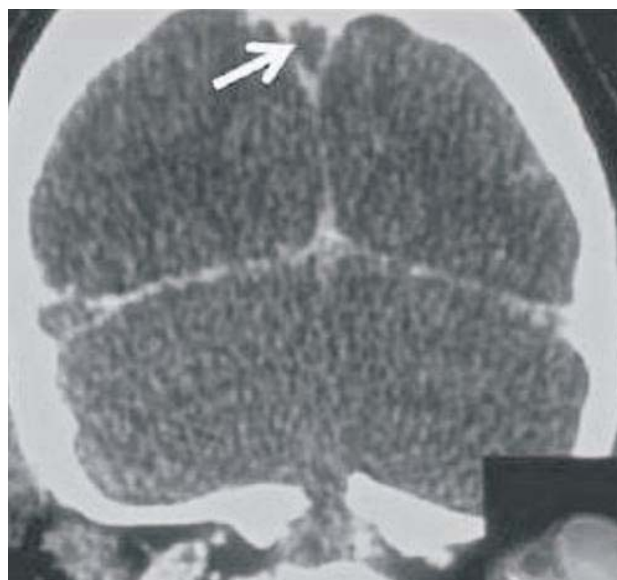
Contrast CT brain (coronal section) shows non-enhancing triangular area (white arrow) surrounded by enhancing dura – empty delta sign.
